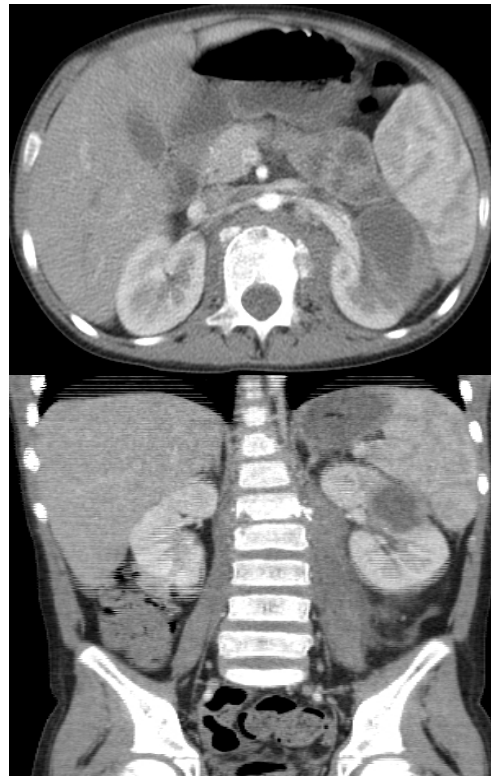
Chest and pelvis CT 07.02.2014*
